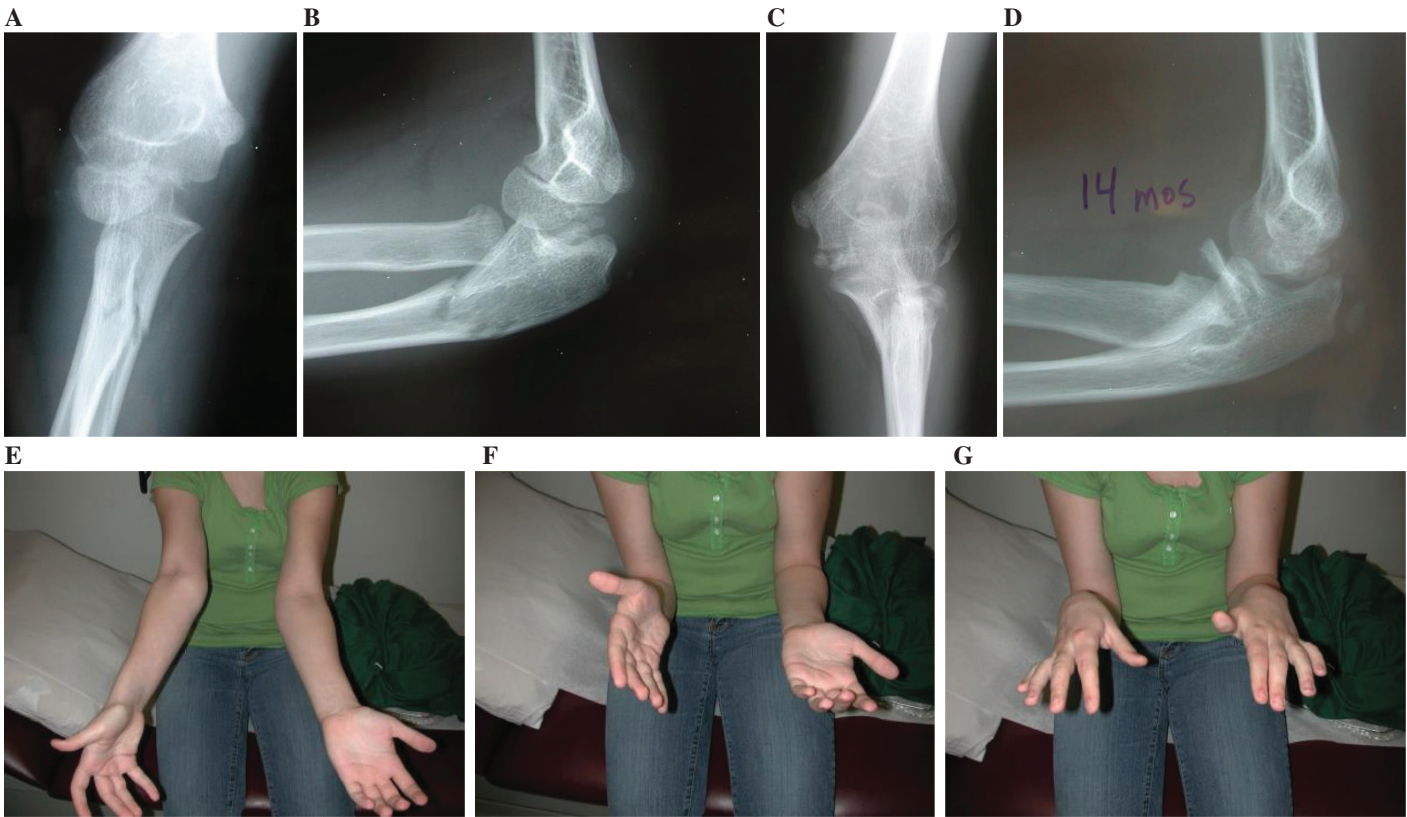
AP (A) and lateral (B) radiograph of the right elbow in a 9-year-old female with acute radial neck fracture and proximal ulna fracture treated with immobilization. AP (C) and lateral (D) radiographs at 14-months follow-up demonstrating healed ulna fracture and radial neck nonunion which was treated conservatively. Patient 16 years of age with residual cubitus valgus (E), limited supination (F), and limited pronation (G) with no pain.
